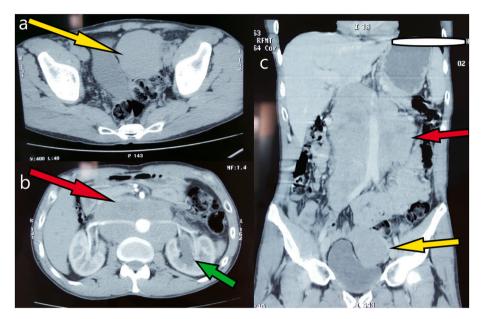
Axials (a & b) and coronal (c) section of plain CT abdomen showing: the left pelvic mass as a tissue lesion with low contrast enhancement, measuring 63×63 mm, with lobulated contours and exerting pressure on the left side of the bladder (Yellow arrow); Heterogeneous conglomerate of retroperitoneal lymphadenopathy was noted, with some necrotic areas, encasing large abdominal vessels, extended along the right iliac axis over a height of 180 mm on the right side and 110 mm on the left, measuring 135×63 mm transversely (Orange arrow), It displaced the kidneys laterally, causing moderate dilation of the left renal cavities (green arrow).
